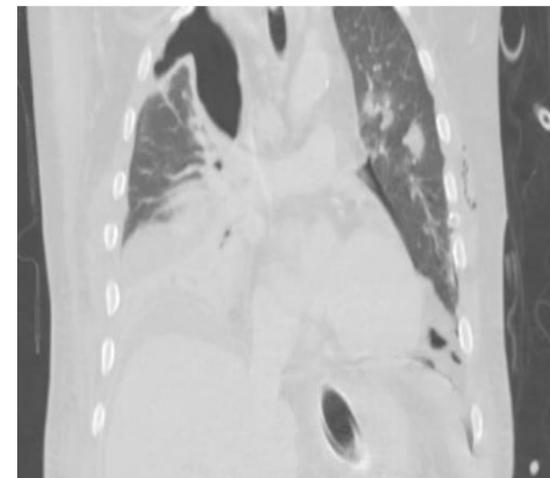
B: Chest CT with Contrast patchy consolidation throughout the lungs bilaterally
